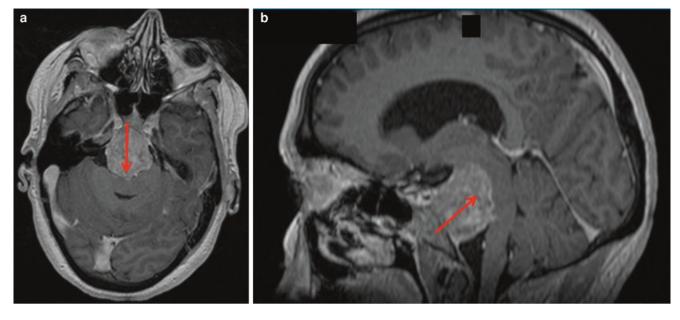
Preoperative axial (a) and sagittal (b) postcontrast volumetric T1-weighted magnetic resonance imaging in a 37-year-old woman with a clival chordoma. Prominent brain stem compression was evident (*arrowed*). The Milan Complexity Scale score was 6, comprising 3
